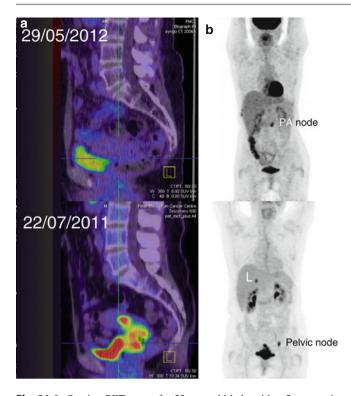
Staging PET scan of a 53-year-old lady with a 5 cm carcinoma of cervix (FIGO stage IIb), performed on July 22, 2011. The PET scan demonstrates the cervical primary with extension into the uterus and an FDG-avid left external iliac lymph node. Interestingly, an FDGavid 15 mm lesion was seen in the liver. This is an unusual pattern of uptake as liver metastases without extensive adenopathy are very rare in cervical cancer, and thus, biopsy was recommended (a). This patient was treated with chemoradiation for her cervix cancer until October 31, 2011. Interestingly, the liver lesion was biopsied on January 25, 2012, and was found to be an intrahepatic cholangiocarcinoma which was then surgically resected. Surveillance PET scan for this patient was performed on May 29, 2012 - 7 months after completing chemoradiation treatment for the cervical cancer. There was no residual uptake seen in the primary tumor and there was complete resolution of the left pelvic lymph node. A new FDG-avid nodal mass behind the left renal vein was present. There were no distant metastases. The activity seen in multiple right ribs is related to previous traumatic rib fractures (b)
